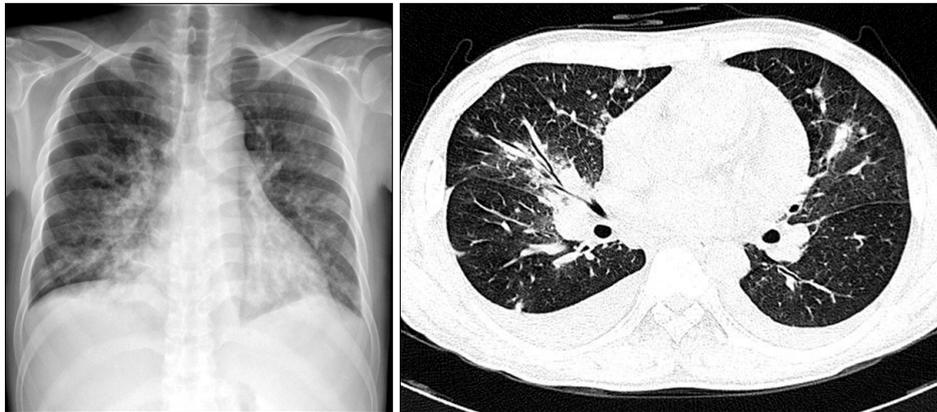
Chest PA on hospital day and Chest HRCT of the patient, Chest radiology show multifocal nodular consolidation and patchy ground glass opacity with air bronchogram and interlobular septal thickening.
